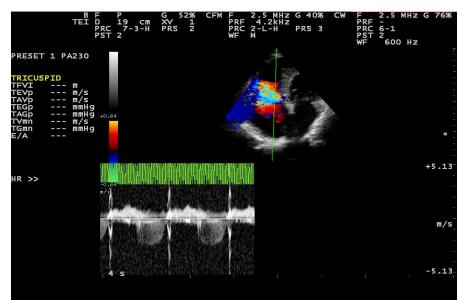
Continuous wave Doppler assesses the blood flow in of tricuspid valve
